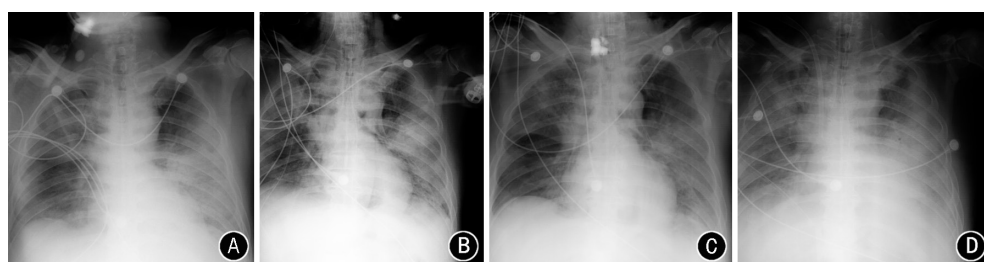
Four images of a 58-year-old male (the same patient of Figure 1A) were obtained on days one (A), three (B), five (C) and seven (D) after admission. Chest X-ray shows bilateral diffuse lung lesions that mildly progressed on day three, mildly absorbed on day five, and finally extensively progressed on day seven during treatment.
